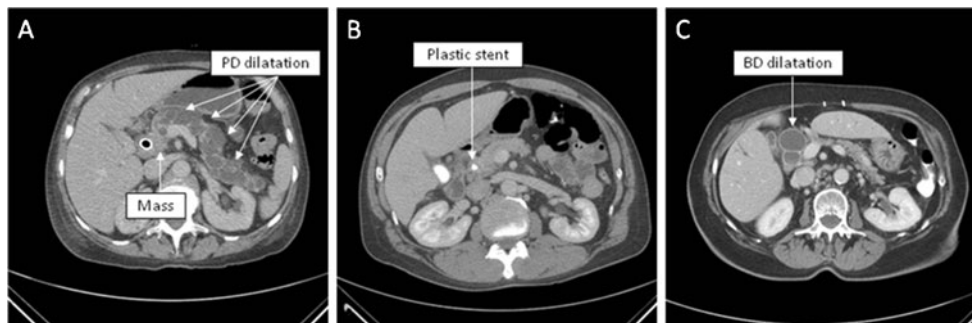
Typical presentations of periampullary adenocarcinoma subtypes on CT based on radiographic features of the mass and associated ducts. a A PDA presents as a heterogenous pancreatic head mass with diffuse PD dilatation and pancreatic tail atrophy. b A BDA is not easily visualized. A biliary stent is present, without any associated PD or BD
